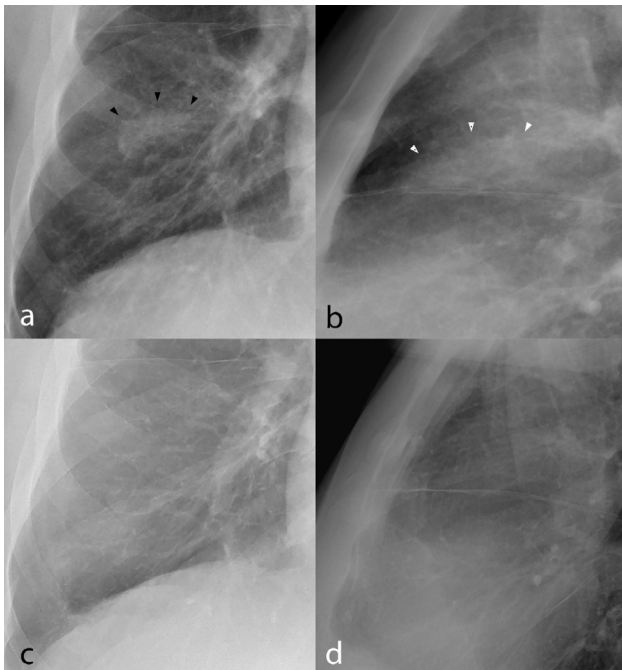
The patient's past medical history reveals three episodes of pneumonia before the described emergency visits. In one episode, a middle lobe infiltrate was revealed on a p.a. (a) and lateral plain chest radiograph (b) (between arrowheads). For comparison, a plain chest radiograph in p.a. (c) and lateral projections (d) taken before the diagnosis of VEXAS syndrome. p.a. = posteroanterior, VEXAS = Vacuoles, E1 enzyme, X-linked, autoinflammatory, somatic.
